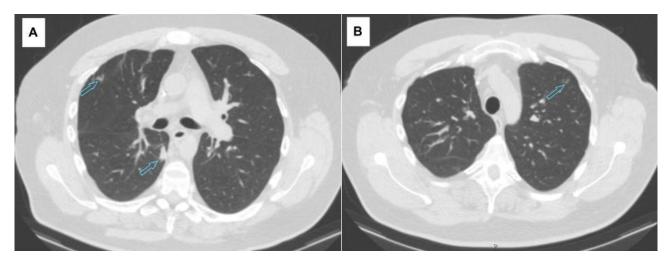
and 3B. Axial thoracic computed tomography with several pulmonary inflammatory infiltrates (blue arrows).
